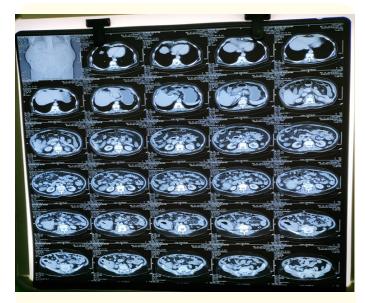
CT SCAN-Mass lesion in caecum and proximal ascending colon.
